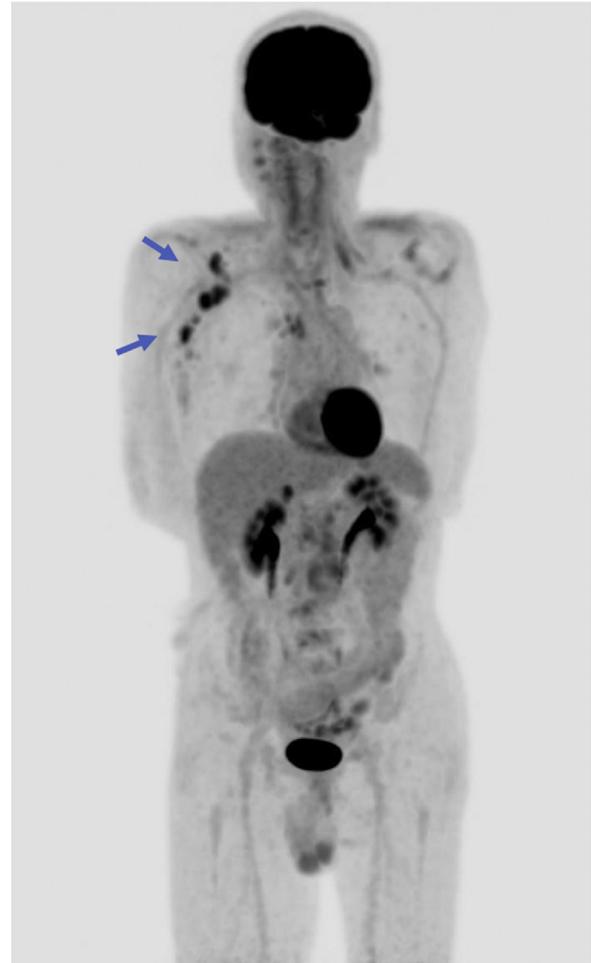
Follow-up positron emission tomographic/computed tomographic image. Multiple distant lymph node metastases were detected 11 months after the completion of bioradiotherapy (blue arrows).
